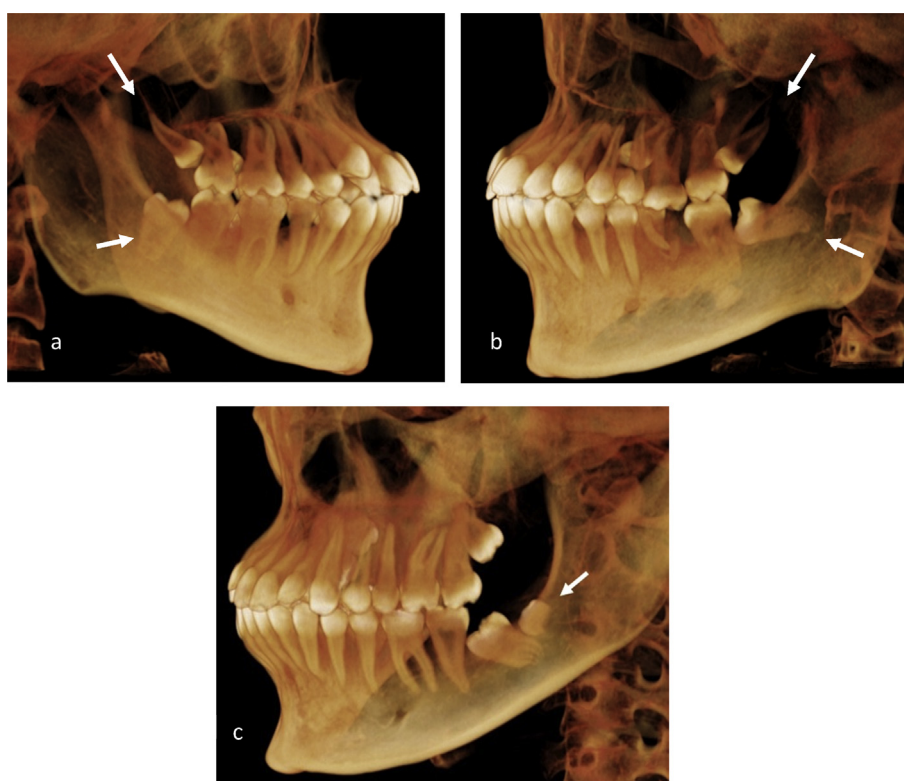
(a) and (b) Three-dimensional CBCT view showing impacted maxillary and mandibular right and left third molars. (c) Three-dimensional CBCT view showing supernumerary tooth at the left mandibular molar.
